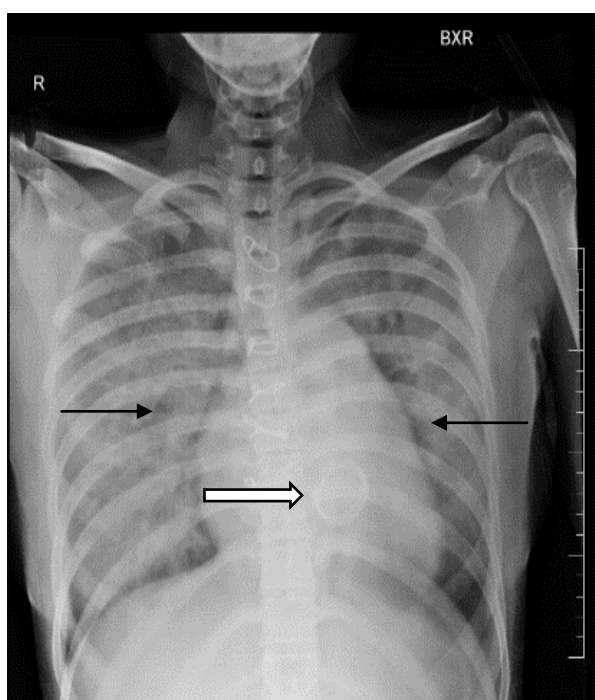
Chest X-ray PA view
